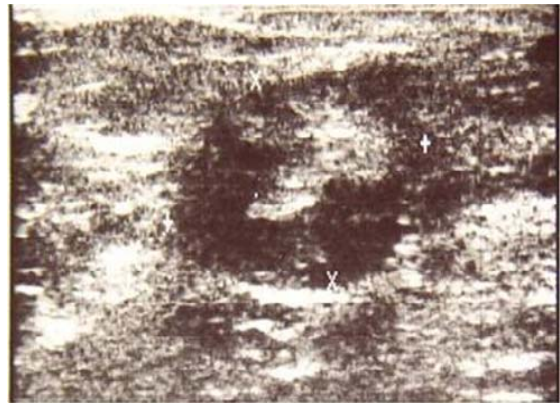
Sonogram shows a cystic mass with an intracystic solid component and echogenic internal septa.
